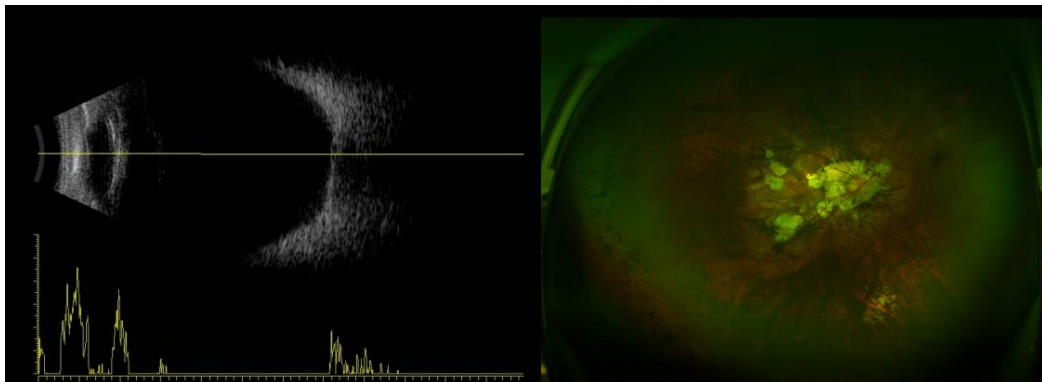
Postoperative follow-up B-ultrasound and fundus examination of the right eye: no residual cysticercus cysts were found
